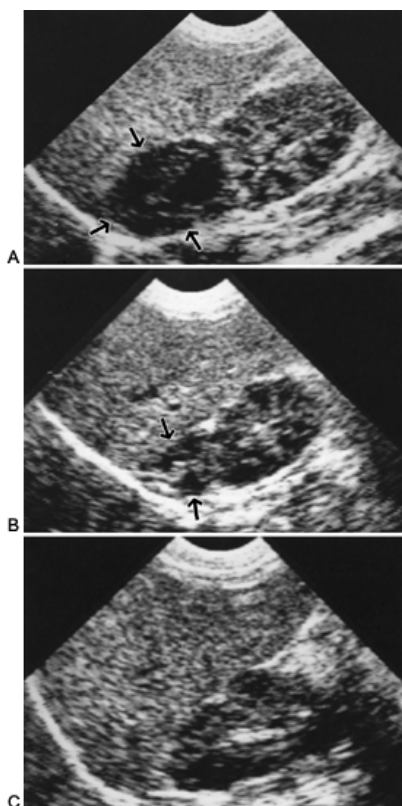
Patient at 17 days of age, ultrasound of adrenal hemorrhage. A: A 4.0-by-3.7-by-2.7-cm complex mass (*arrows*) in region of right adrenal gland. Echolucent areas suggest liquefaction. B: Patient at 1 month of age. The mass (*arrows*) has diminished in size, measuring 2.0 by 1.5 cm. C: Patient at 2 months of age. Adrenal gland is normal. Adrenal hemorrhage has resolved completely.
